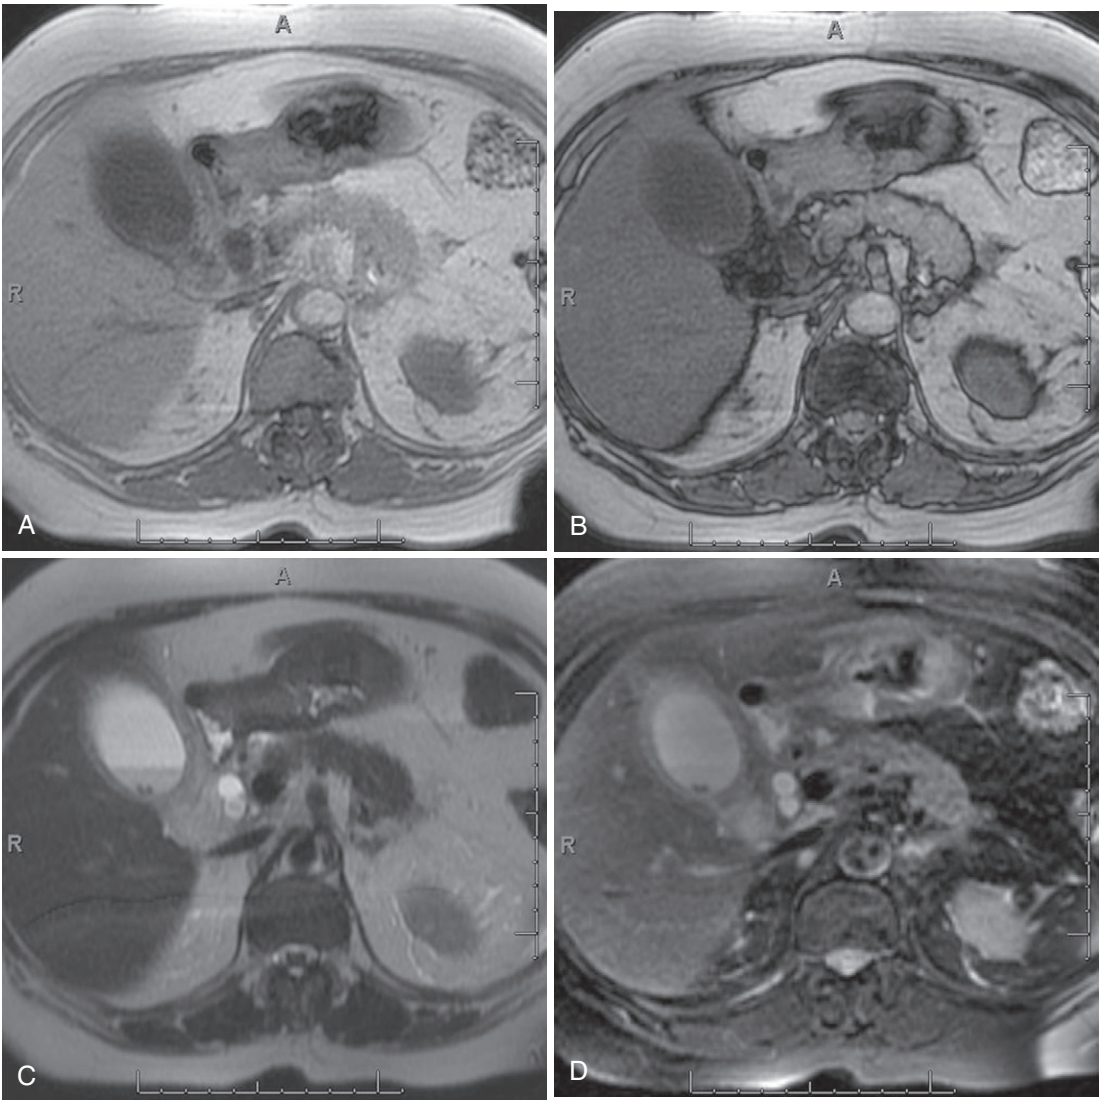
Acute cholecystitis. In-phase (A) and out-of-phase (B) T1-weighted, T2-weighted (C), fat-suppressed T2-weighted (D), and precontrast (E) and postcontrast (F) fat-suppressed T1-weighted gradient recalled-echo images demonstrate gallstones, mural thickening, mural hyperemia, and adjacent hepatic hyperemia of acute cholecystitis caused by an obstructing T1 hyperintense gallstone within the cystic duct (*arrow* in E).
